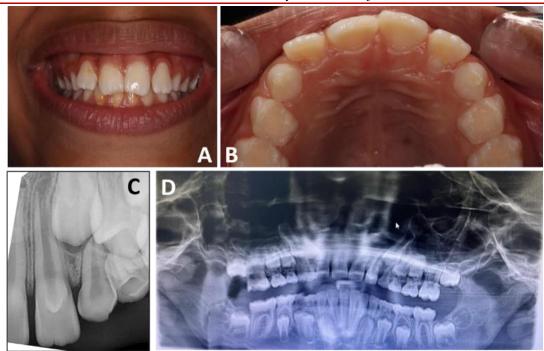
case #1 with type 2 talon cusp: Frontal View (A), Occlusal View(B), Periapical View (C), Panoramic View (D)
